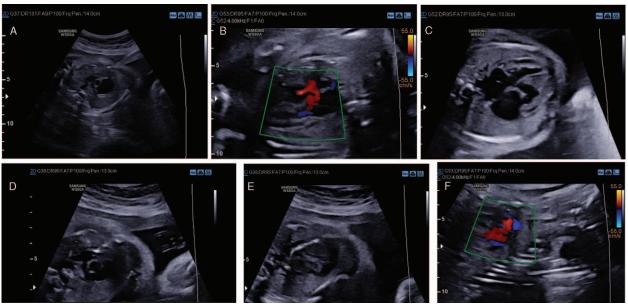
Fetal pulmonary valvuloplasty in the fetus at the 26th week of gestation. (A) Echocardiography showed pulmonary atresia. (B) Doppler ultrasound showed no forward flow of pulmonary valve. (C) Echocardiography showed small right ventricular cavity, myocardial hypertrophy, and right ventricular dysplasia. (D) Echocardiography showed the needle tip was pushed through the pulmonary valve in the valve middle for perforation. (E) The coronary balloon (3.5 mm × 12.0 mm; Boston Scientific, USA) was sent in along the guidewire to dilate the pulmonary value. (F) Doppler ultrasound showed pulmonary valve forward flow recovery after operation.
